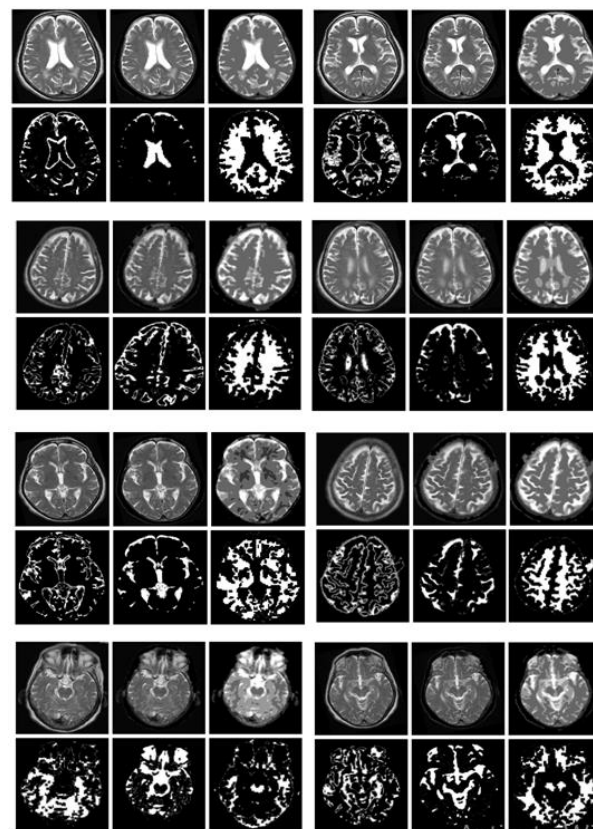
Separating GM, WM, and CSF regions from MRI slices of an MS patient
